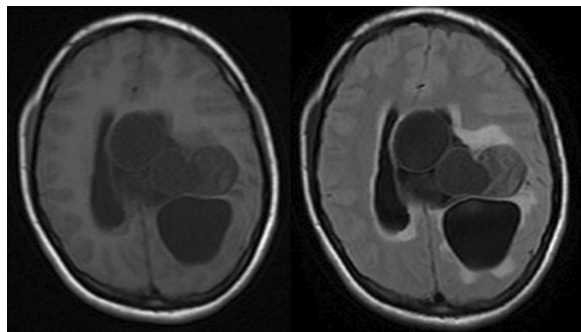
Axial T1WI and FLAIR shows multiloculated multicystic lesion in left lateral ventricle and adjacent periventricular deep white matter. FLAIR shows perilesional edema
